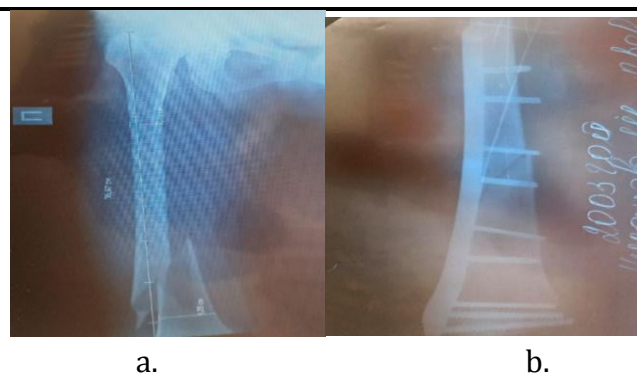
Radiograph of patient Sh., born in 1989. a-diagnostic before surgery, b-after surgery, Liss fixation.
